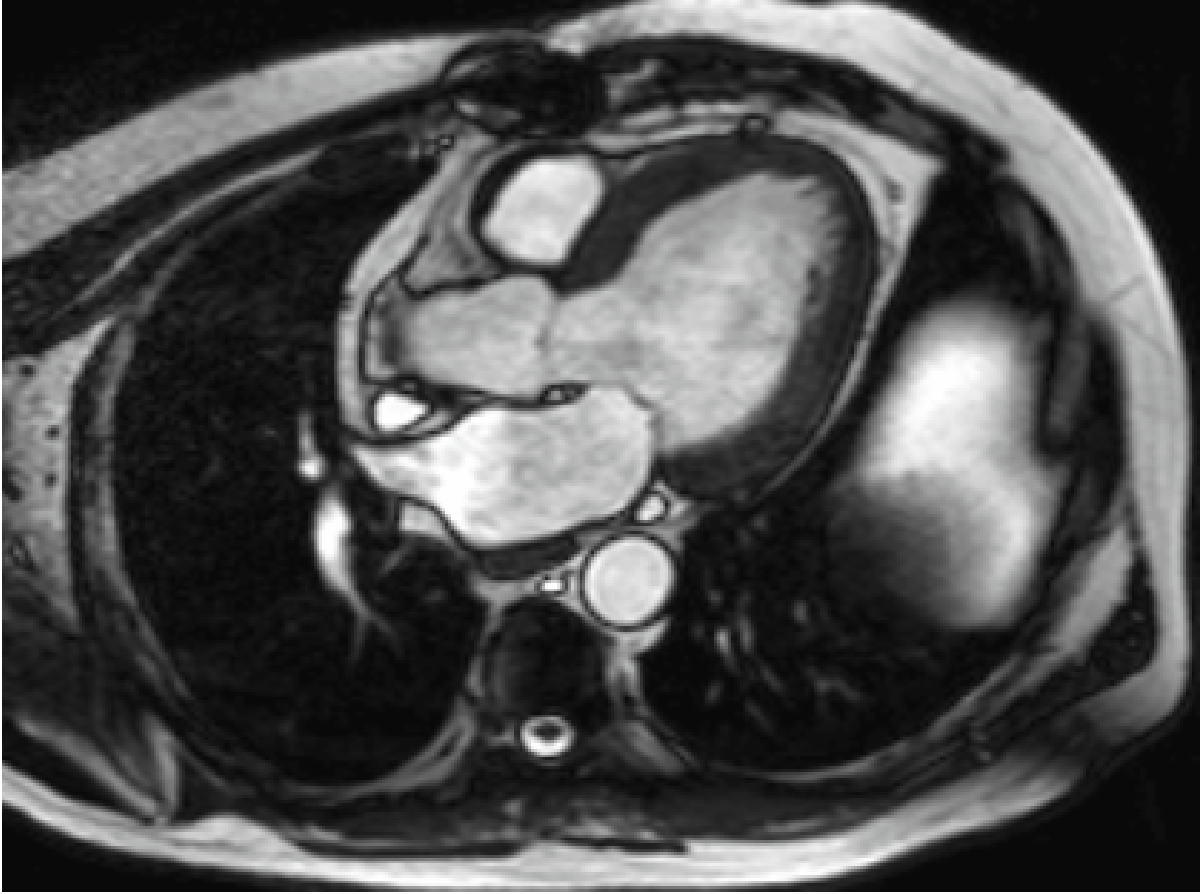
Cardiac MRI image depicting the left atrium, left ventricle, aorta, mitral valve and aortic valve (Courtesy of Center for Medical Imaging and Physiology, Department of Clinical Physiology at Lund University)
